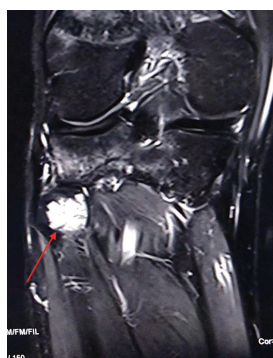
STIR magnetic resonance imaging coronal image with a hyperintense signal intensity in the right proximal fibula (arrow).
